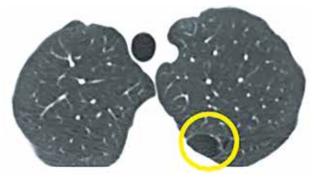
Chest CT image with yellow circle depicting left posterior lung cyst that is not fluid-filled. CT done three years later.
